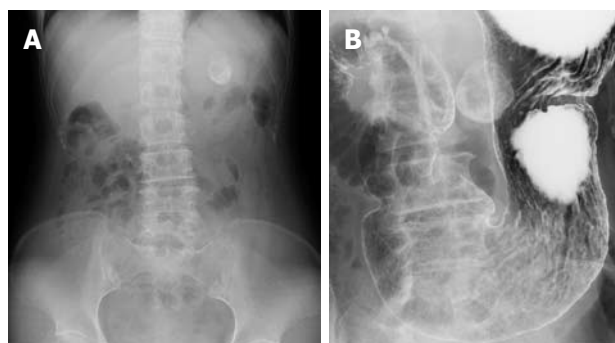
Radiological findings. A: Abdominal X-ray indicated a spherical calcified lesion in the left upper quadrant; B: Barium study showed a round calcification bordering the gastric wall.
